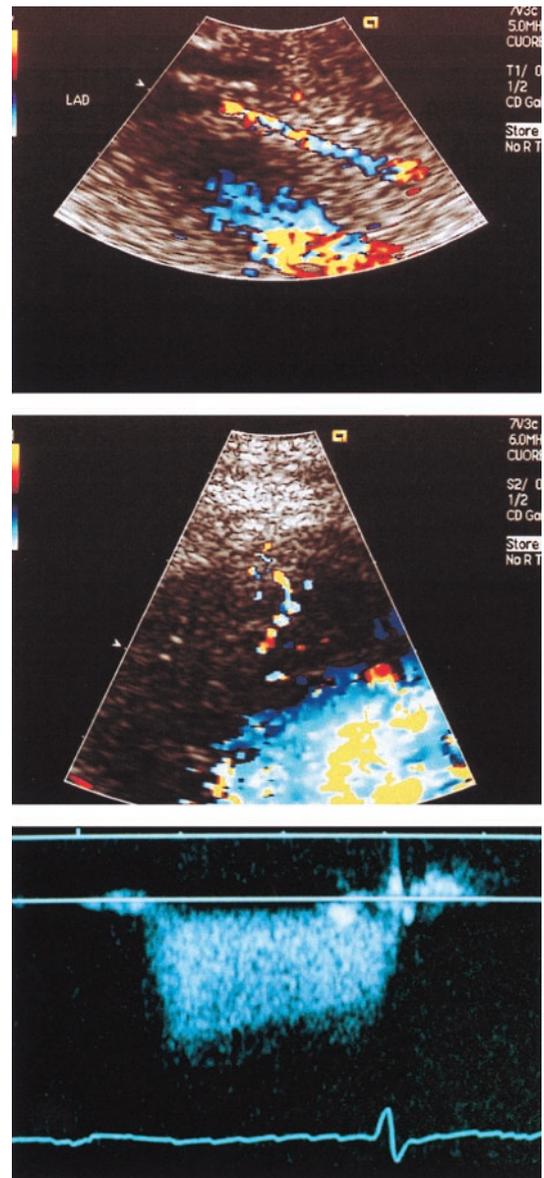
Transthoracic color Doppler echocardiography showing the distal left anterior descending coronary artery (top), a peripical perforating branch (middle) and the characteristic diastolic pattern of coronary flow velocity (bottom).
